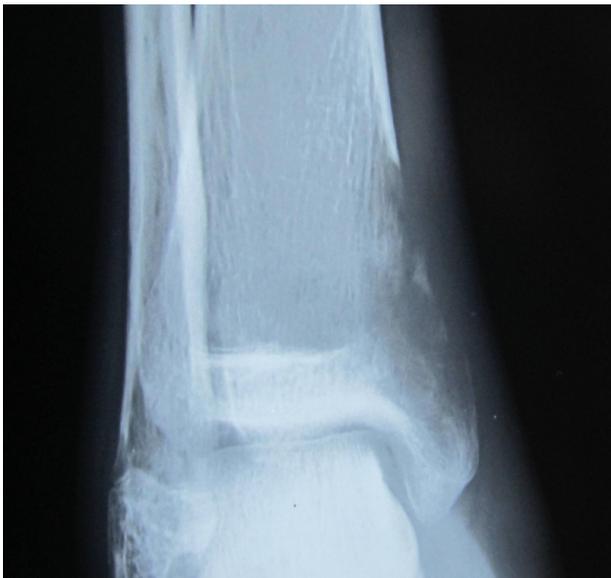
X-ray Left ankle joint AP view (Lytic Lesion Tibial malleolus).
